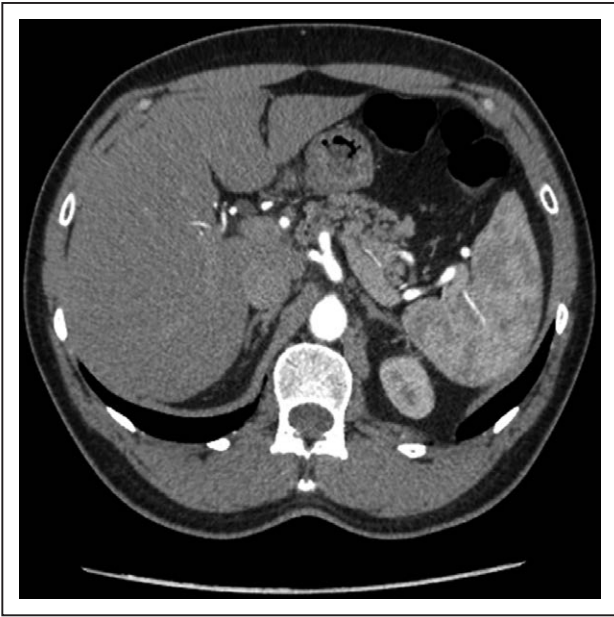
Computed tomographic scan showing 2 normal adrenals.
